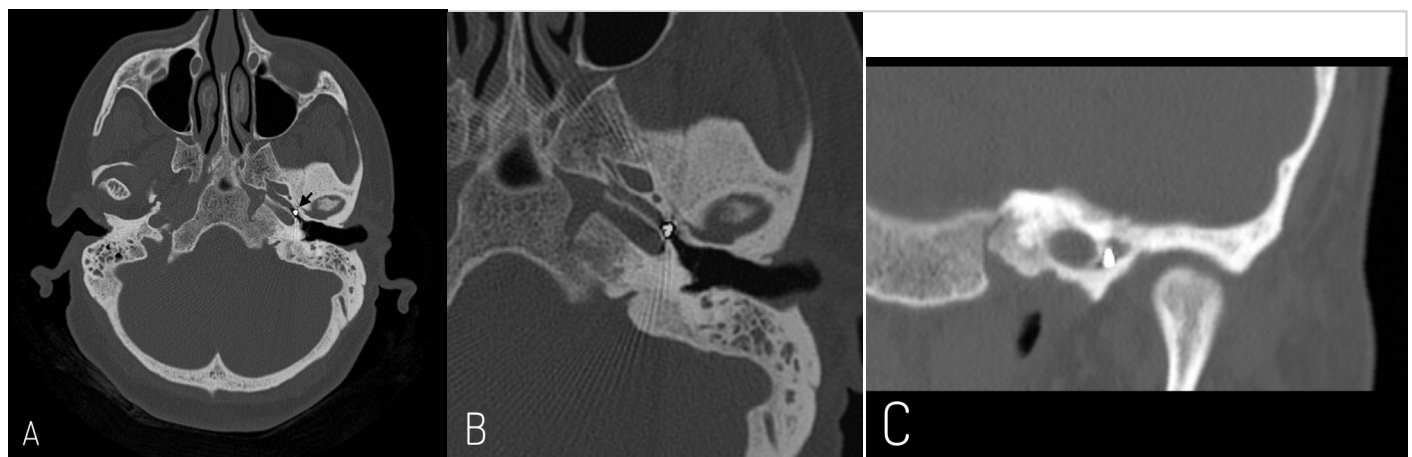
Computed tomography scan, temporal bones. Axial section (A) showing a foreign body in left Eustachian tube (arrow). Magnified axial (B) and coronal (C) sections demonstrating the proximity to the carotid artery
